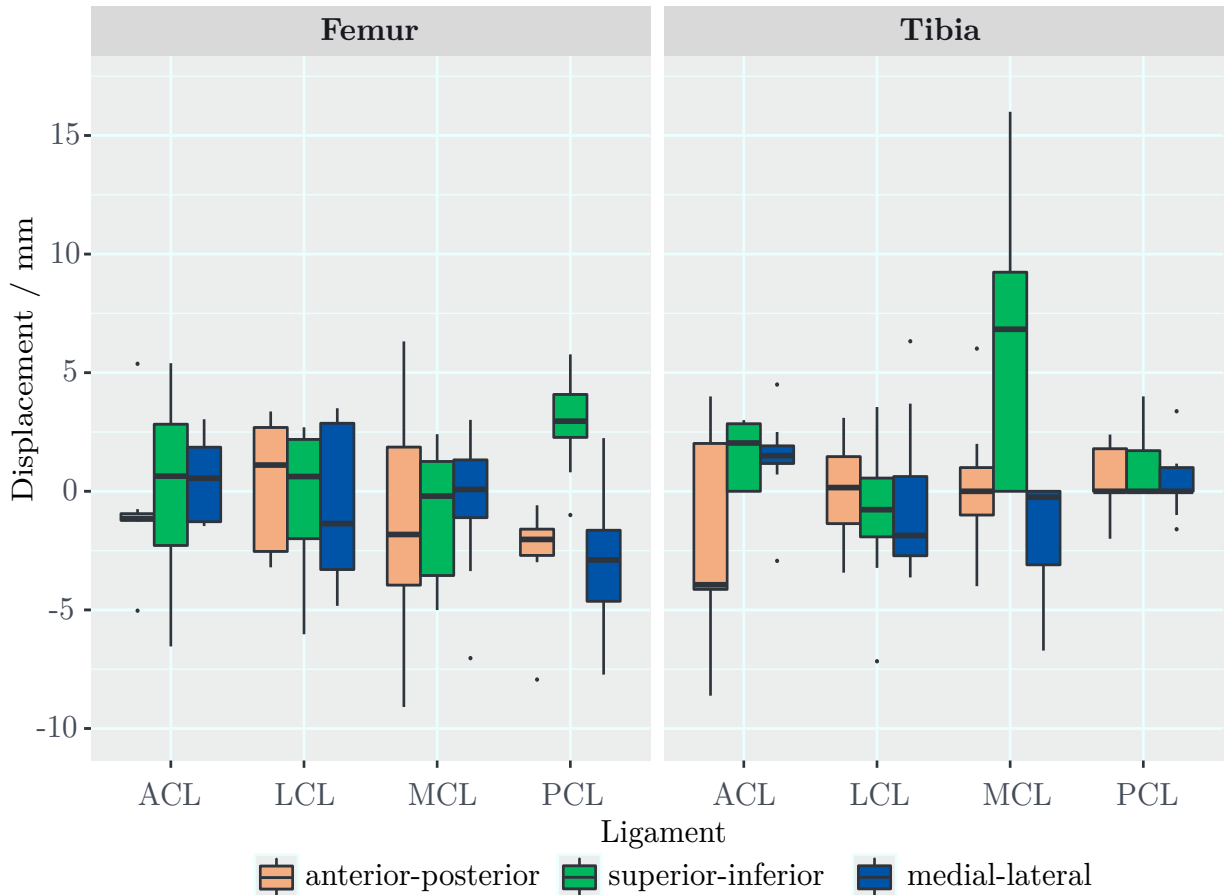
Accuracy of the radial basis function based approximation of the ligament attachment sites of the MCL, LCL, ACL, and PCL for the femur and the tibia. Differences in relation to the MRI based attachment site estimation in three directions are displayed.
